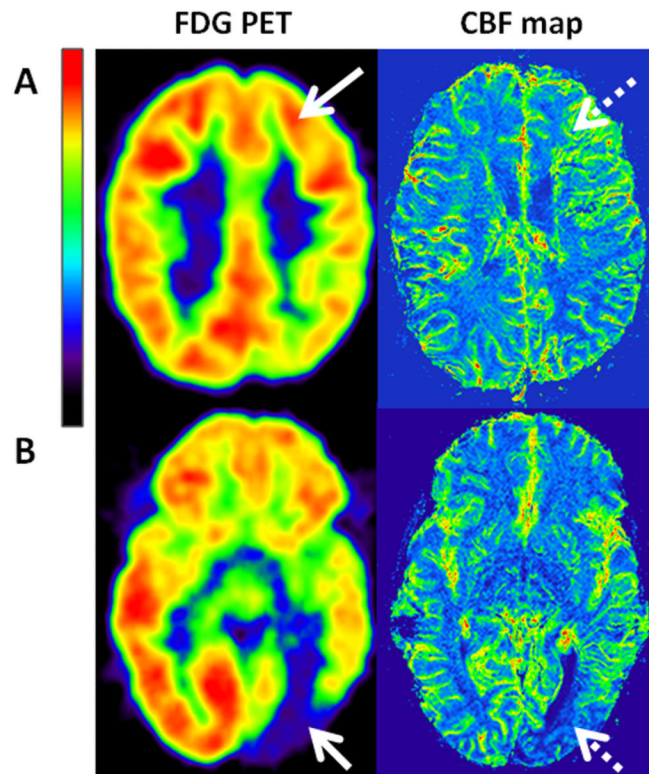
Representative axial slices of FDG PET scans and cerebral blood flow (CBF) maps of two patients. Panel A depicts the normometabolic left frontal lobe (FDG AI=-5%; arrow) of patient #4. PWI demonstrated increased CBF (AI=36%) in the underlying white matter (dashed arrow). Panel B shows severe cortical glucose hypometabolism of the left occipital lobe (FDG AI= -97%; arrow) of patient #8 and concomitant decreased white matter perfusion in this area (CBF AI= -21%; dashed arrow).
